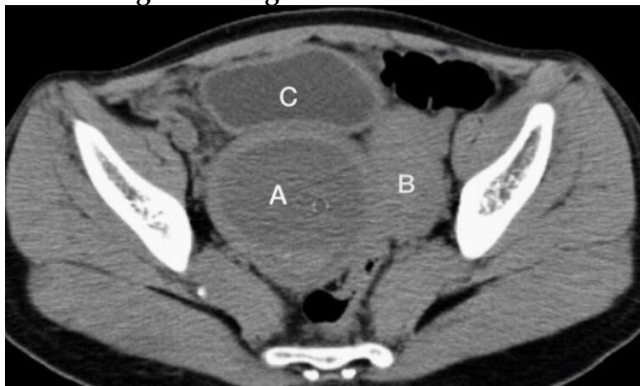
Axial CT image pelvis. A. Right sided haematometrocolpos with thick uniform wall and a fluid-fluid level. B. Displaced left uterine moiety. C. Urinary bladder.
